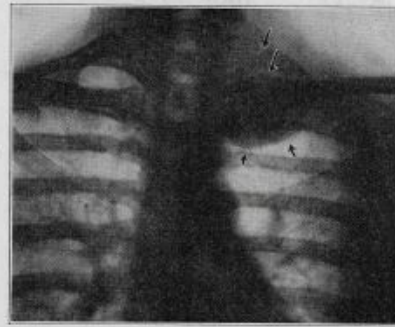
(case 7).—Roentgenogram of the chest, showing the circumscribed apical shadow. Note the upper arrows pointing to the second rib and to the head and neck of the first rib, both of which are intact.
